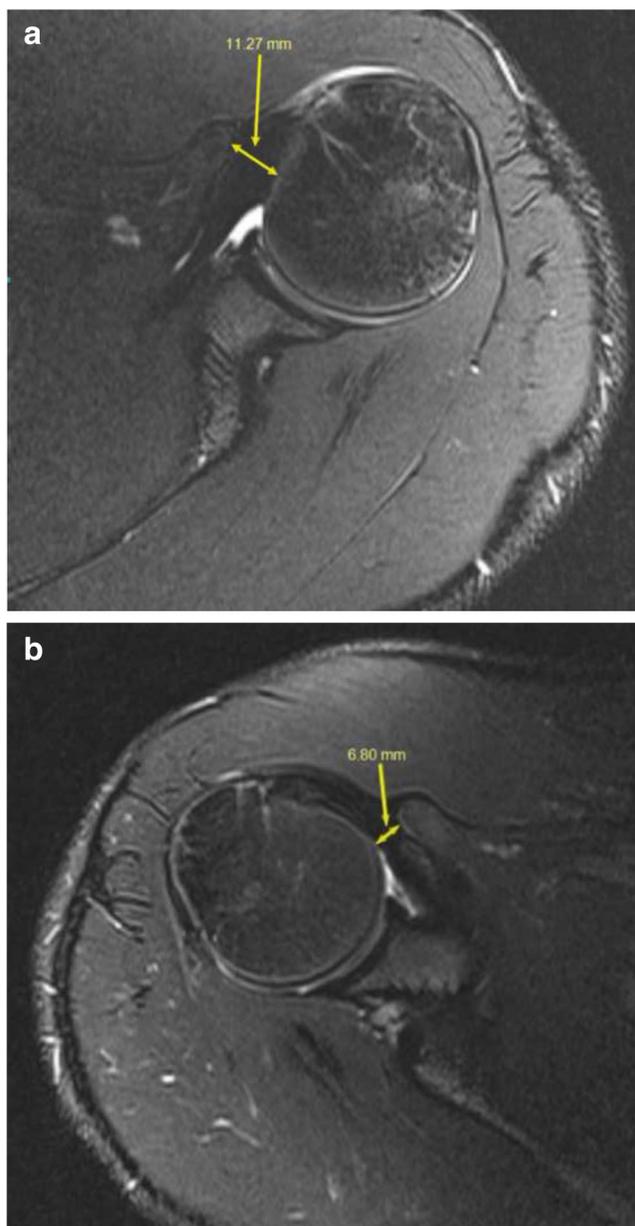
Axial proton density MRI sequence with fat saturation of both shoulders. a Thick subscapularis tendon with broad proximal humeral insertion measuring 12 mm in thickness. b Contralateral image shows normal subscapularis tendon measuring 7 mm in thickness
